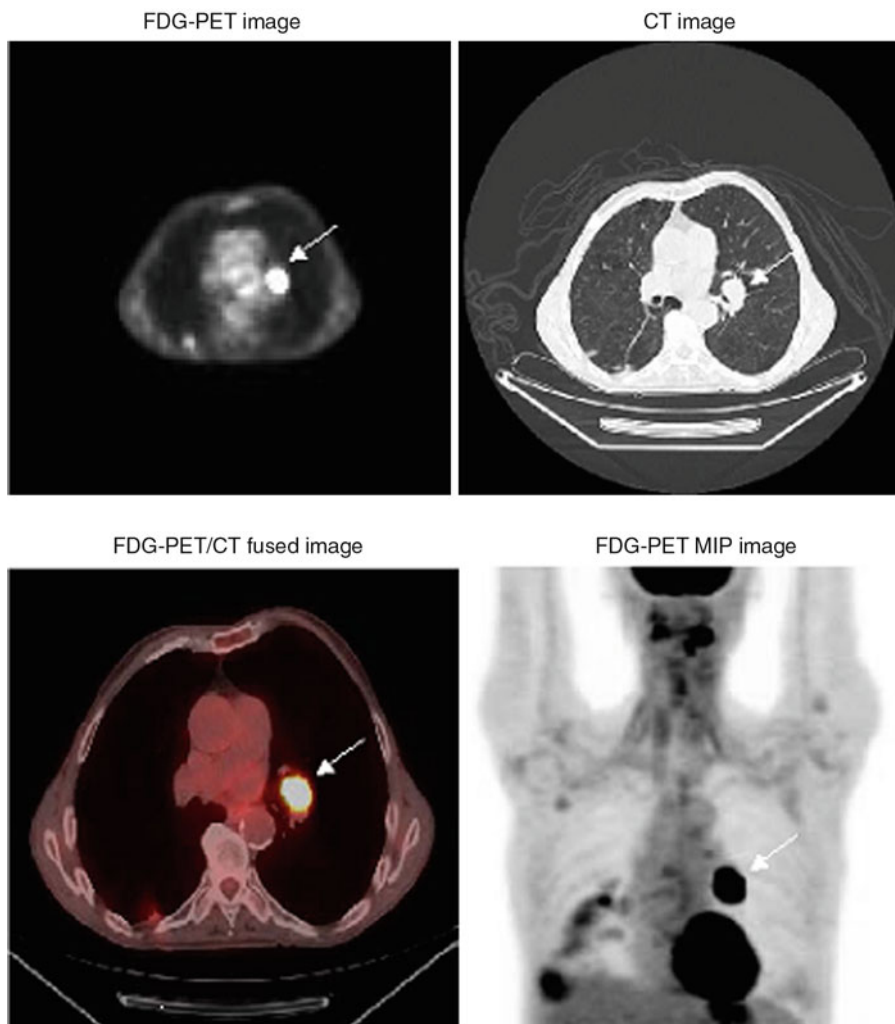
A patient with squamous cell cancer in the tongue who has undergone chemoradiation. FDG-PET/CT images show an active area at left hilar with maximum
